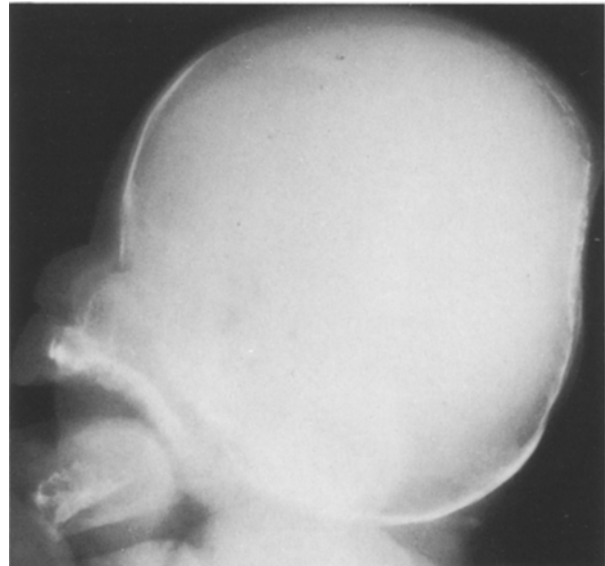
Skull radiograph of a premature infant with OI, showing lack of vault calcification. Although the posterior skull shows irregular ossification, SWBs cannot be defined
